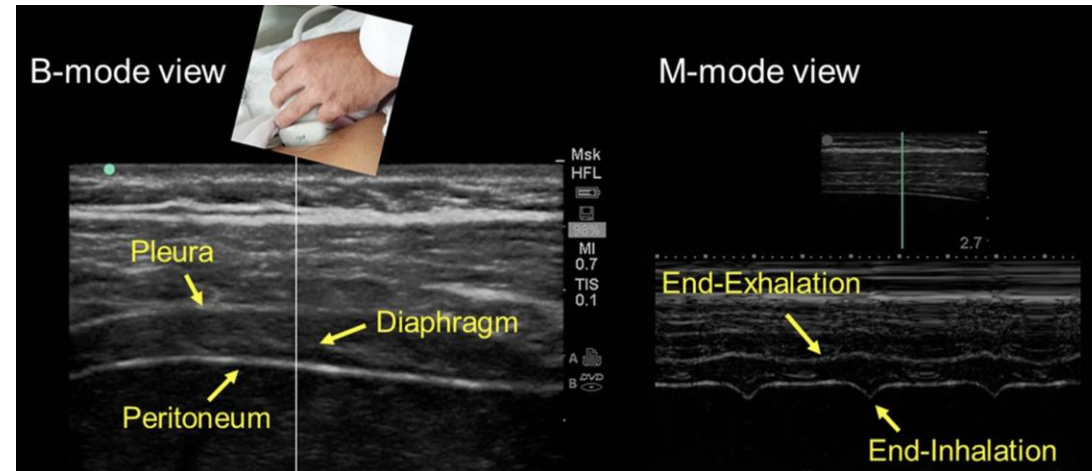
B-mode ultrasound of diaphragm thickness at end-inspiration vs end-expiration (labeled with a double-headed arrow marking thickness change)
